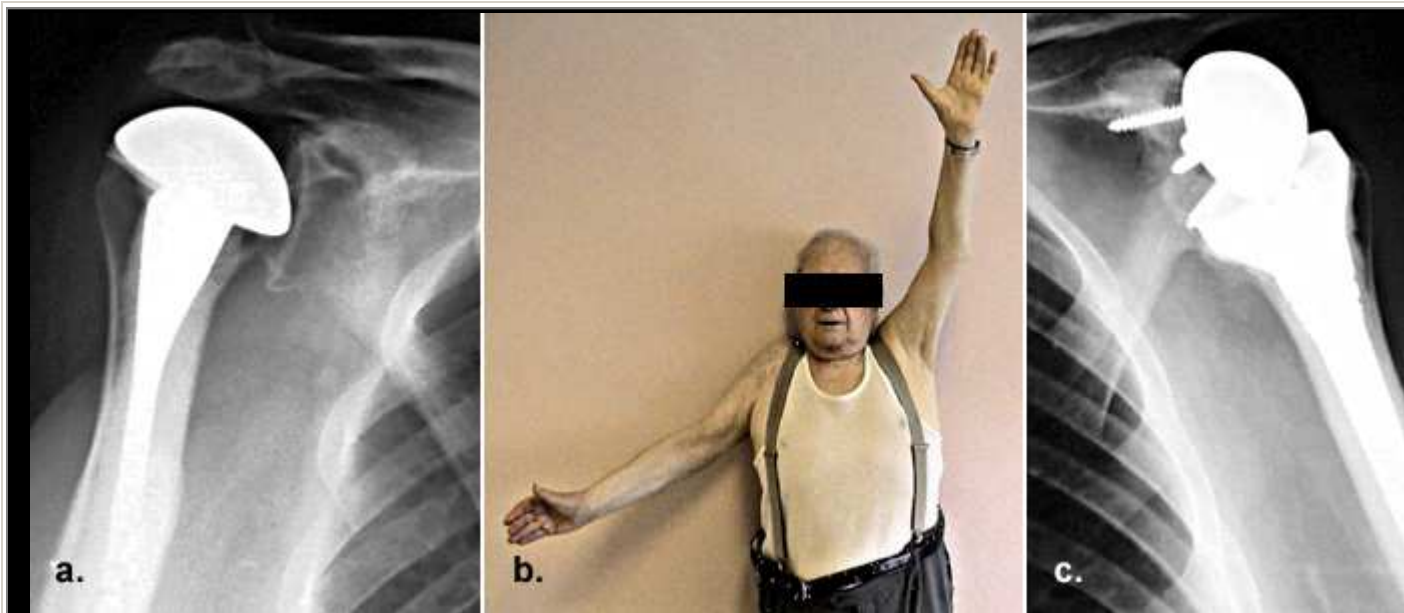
a. An x-ray of the right shoulder of the patient in Figure 3b shows a standard hemiarthroplasty component. b. The patient had both shoulders replaced due to arthritis coupled with massive, irreparable rotator cuff tears. Note that patient has the ability to raise his left arm over his head, but he cannot lift his right arm much. The reverse prosthesis replaced his left shoulder allows him to have better function than he has with his right shoulder. c. An x-ray of the patient's left shoulder shows the reverse prosthesis.
